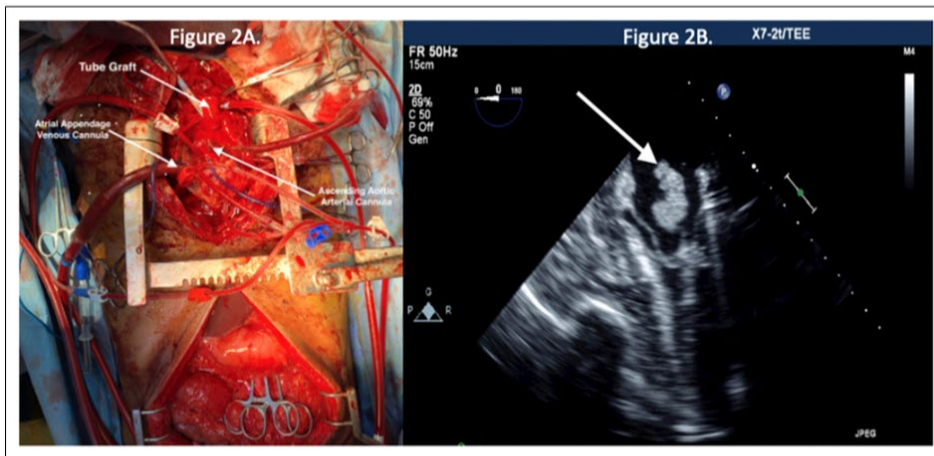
(A). Brachiocephalic artery injury repaired with tube graft while on cardiopulmonary bypass. (B). Transesophageal echocardiogram revealing intraoperative intracardiac thrombus.
